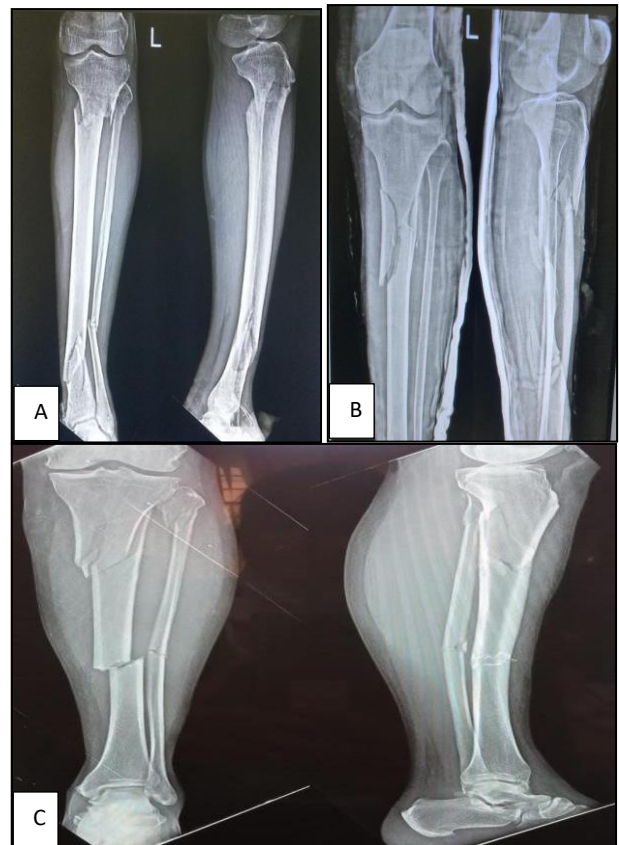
(A-C): Pre op X-rays of segmental fractures and comminuted proximal both bones fractures of leg.
